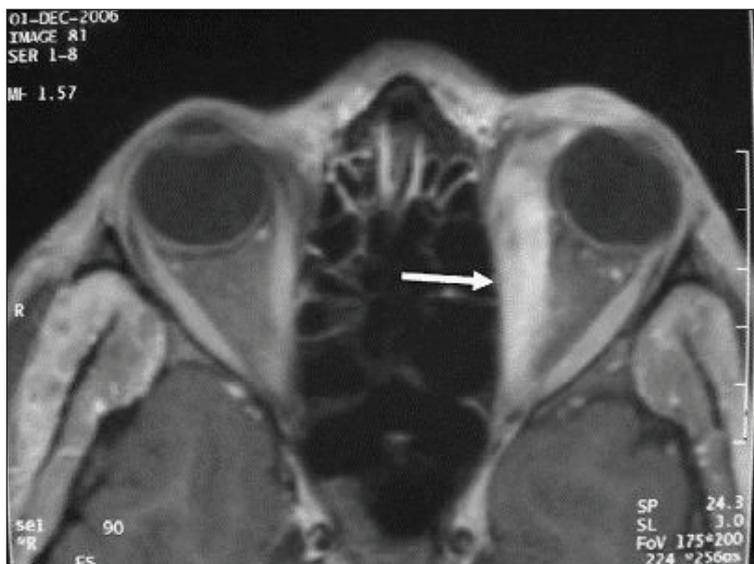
MRI of the orbit showing an increase in signal (arrow) on the left medial rectus muscle.
